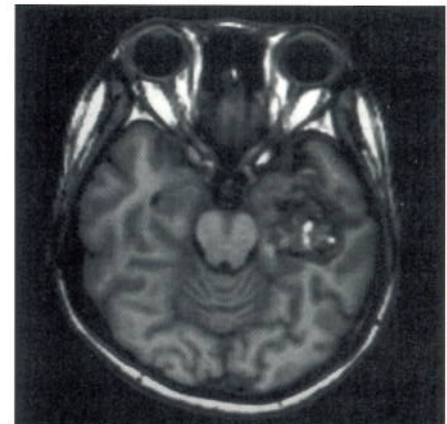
T1-weighted brain shows area of high signal intensity consistent with short T1 blood in the methemoglobin stage of breakdown. This would also show up on a time-of-flight MRA.
